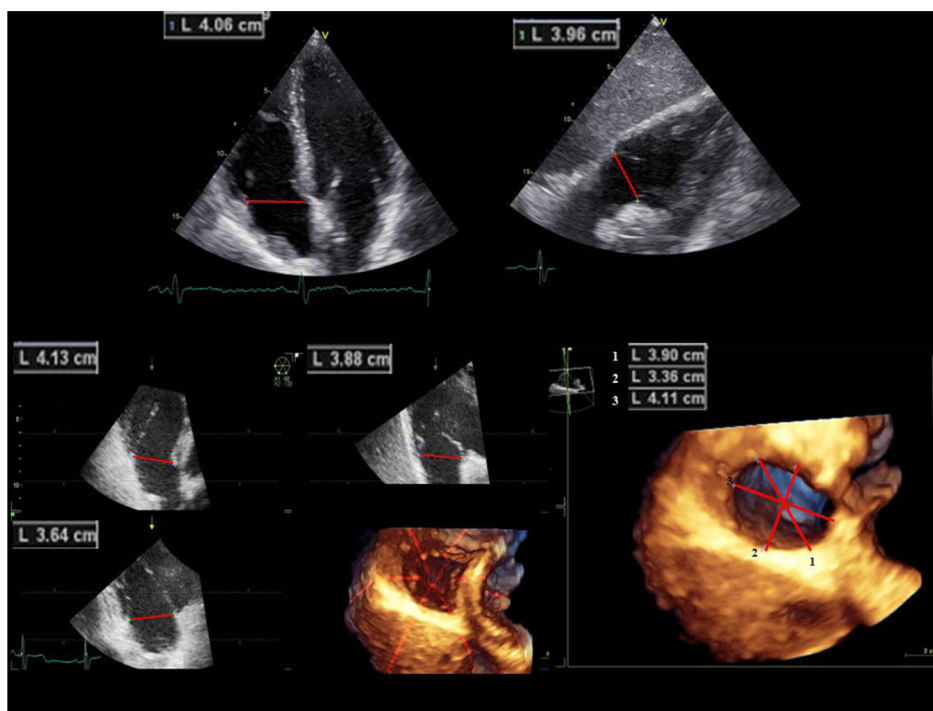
Tricuspid annulus (TA) diameter assessment by two-dimensional (2D) and three-dimensional (3D) transthoracic echocardiography. (Top) 2D apical four-chamber and subcostal long-axis view with end-diastolic TA measurement. (Bottom left) Volume rendering of the TA shown from the right ventricular perspective. The “laser lines” superimposed on the 3D echocardiography rendering indicate the orientation of the corresponding depicted image in the longitudinal 2D views of the tricuspid valve. (Bottom right) Measurements of diameters from the end-diastolic 3D frame of the TA.
